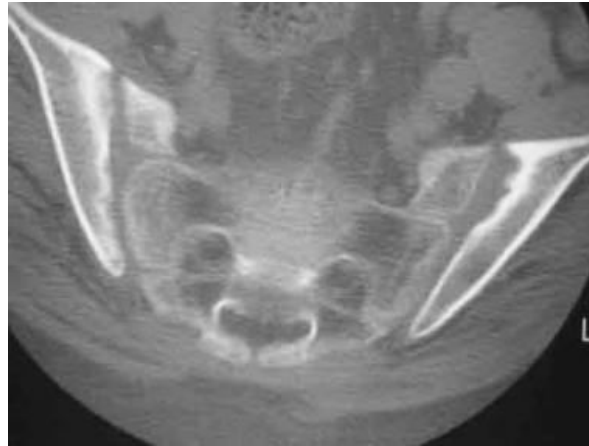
Axial CT scan in AS patient shows erosions and iliac side subchondral sclerosis of both sacroiliac joints. Bilateral sacroiliitis. (22).
